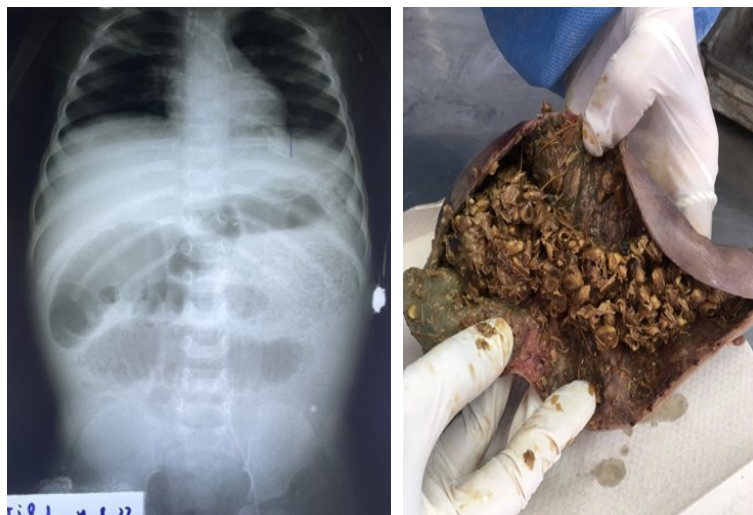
Frontal abdominal X-ray showing a phytobezoar in the intestine. A phytobezoar is a mass of plant material that has accumulated in the stomach or intestines. It can cause a variety of symptoms, including abdominal pain, nausea, vomiting, and constipation. In some cases, surgical removal of the phytobezoar may be necessary.
